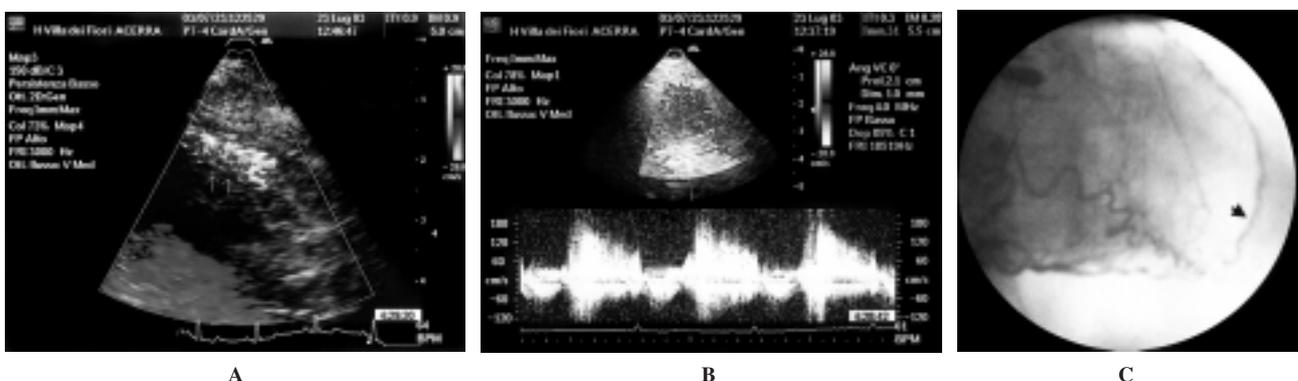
Significant left anterior descending coronary artery stenosis (> 70% diameter narrowing). A: variance effect at color Doppler; B: marked spectral broadening and negative frequencies at pulsed Doppler; C: coronary angiography exhibiting a proximal left anterior descending coronary artery occlusion, with counterflow rehabilitation by the right coronary artery which showed multiple severe stenosis.
